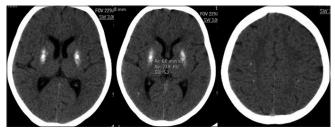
Axial non contrast CT images of brain at the level of basal ganglia confirms calcifications in bilateral lentiform nuclei and few subcortical calcification in bilateral parietal lobes.
